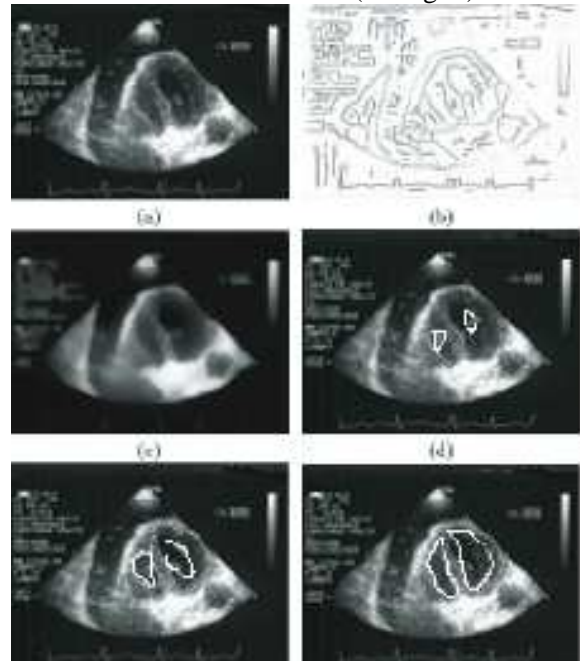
ultrasound image of the heart (top left), Canny-Deriche segmentation (top right), convergence to the asymptotics (medium left) and viability contouring (medium right and bottom)
